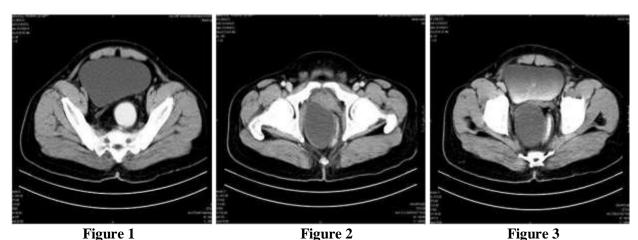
CT SCAN showing the retrorectal mass
